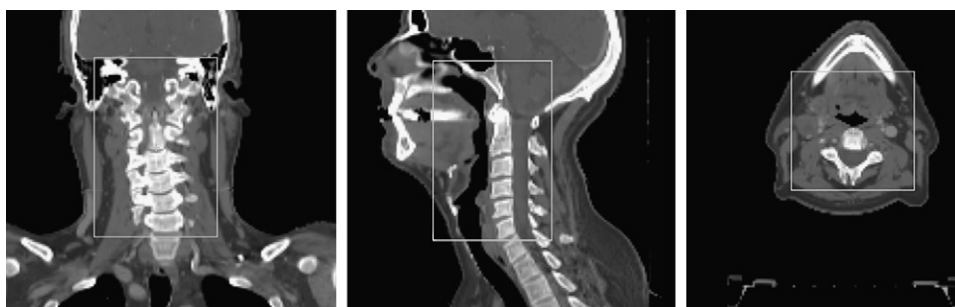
Example of a clip box (white) overlaid on the planning computed tomography scan in the coronal (left), sagittal (middle), and axial (right) planes.
